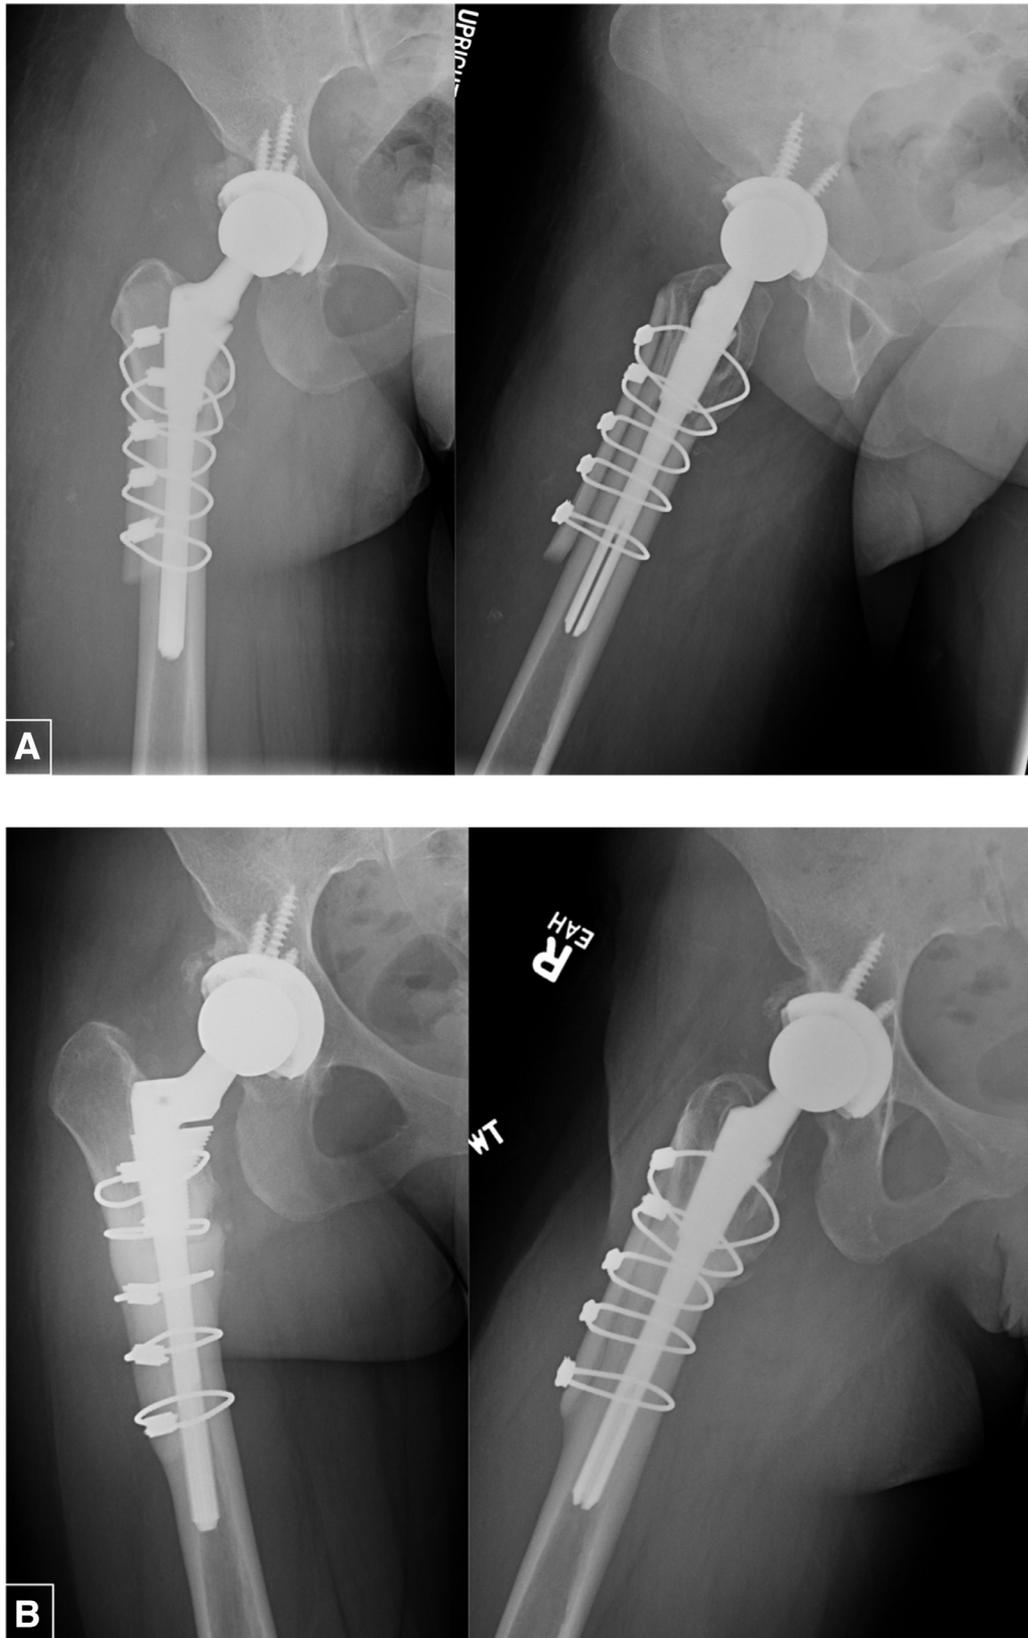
A 26-year-old female with DDH status post RTHA with acetabular medialization and subtrochanteric shortening osteotomy. (a) Immediate postop, cortical strut graft cerclage wires. (b) Two years post-op, radiographs show excellent healing.
